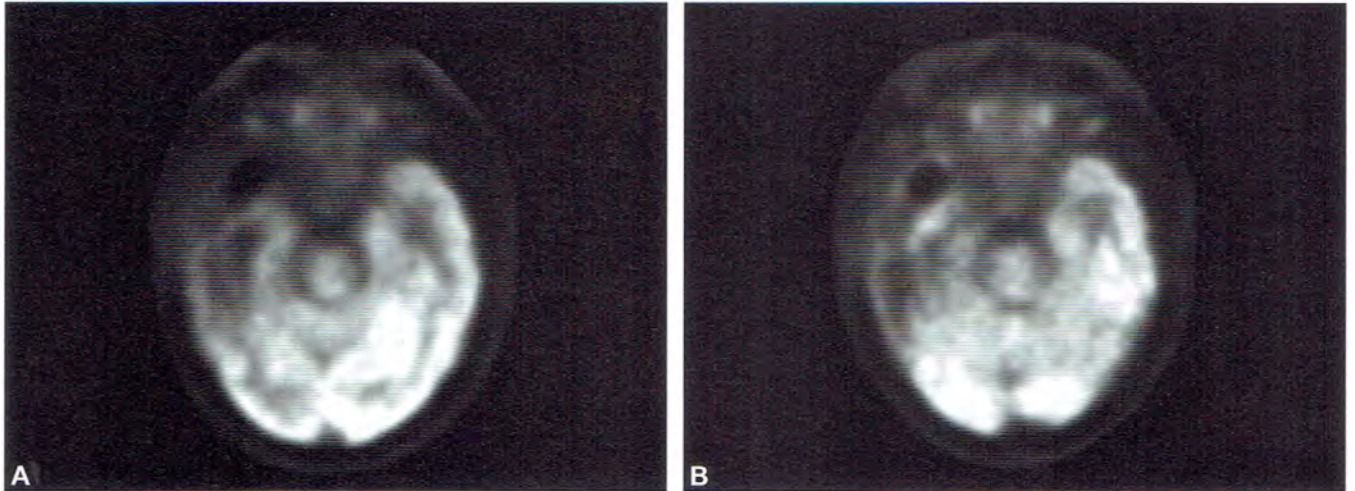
to D: These images all demonstrate FDG activity at the periphery of an enhancing right temporal lobe mass with a hypometabolic center. The question is if this is active tumor or radiation necrosis, and unfortunately, this could not be determined. The time between the radiation therapy and this scan is too short and postradiation activity could still be present. A follow-up brain PET/CT in 3-4 weeks was requested.
